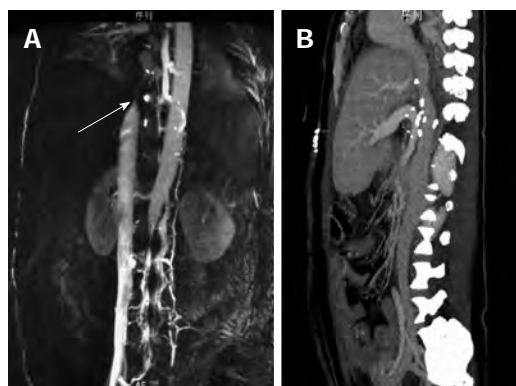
The inferior vena cava. A: Pretreatment of stenosis in inferior vena cava (IVC) on magnetic resonance venogram imaging (arrow); B: One year after patch repair, computed tomography angiography showed no obvious obstruction in the IVC and good hepatic vein outflow.
